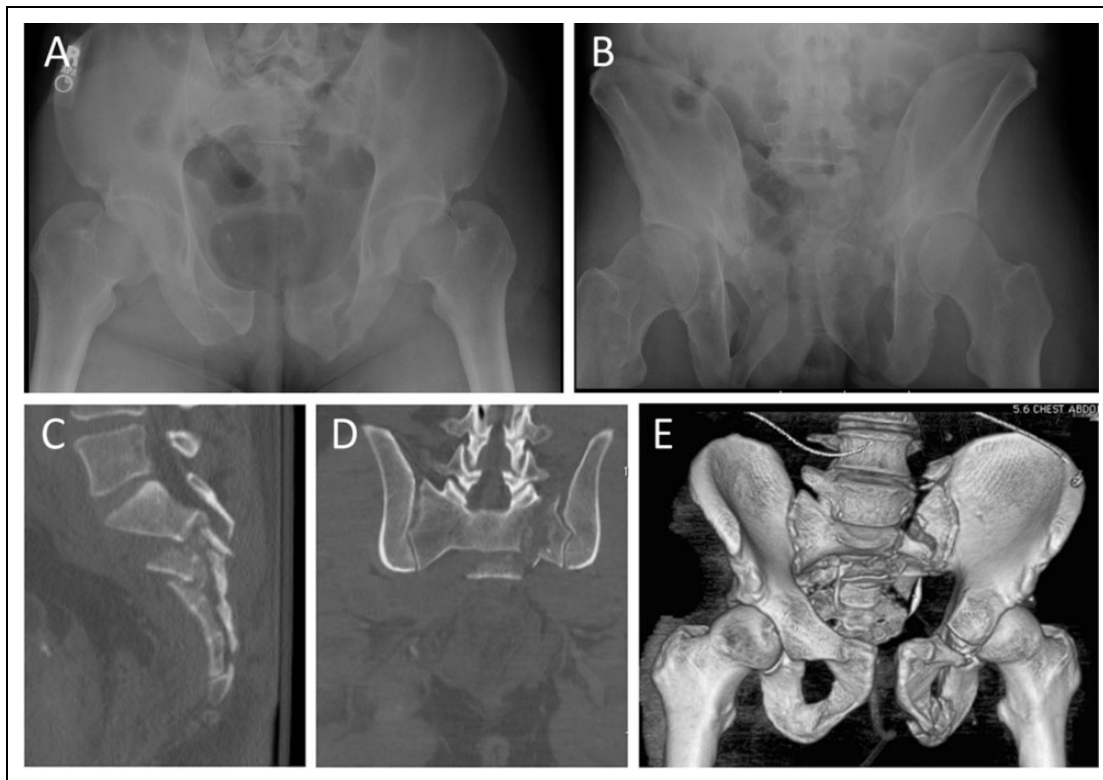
(A, B) Plain radiographs of a 53-year-old male with an unstable pelvis fracture. While it is visible on the radiographs, the complexities of the fracture are much more apparent on the sagittal (C), coronal (D), and 3-dimensional reconstruction (E) images from a computed tomography scan.
